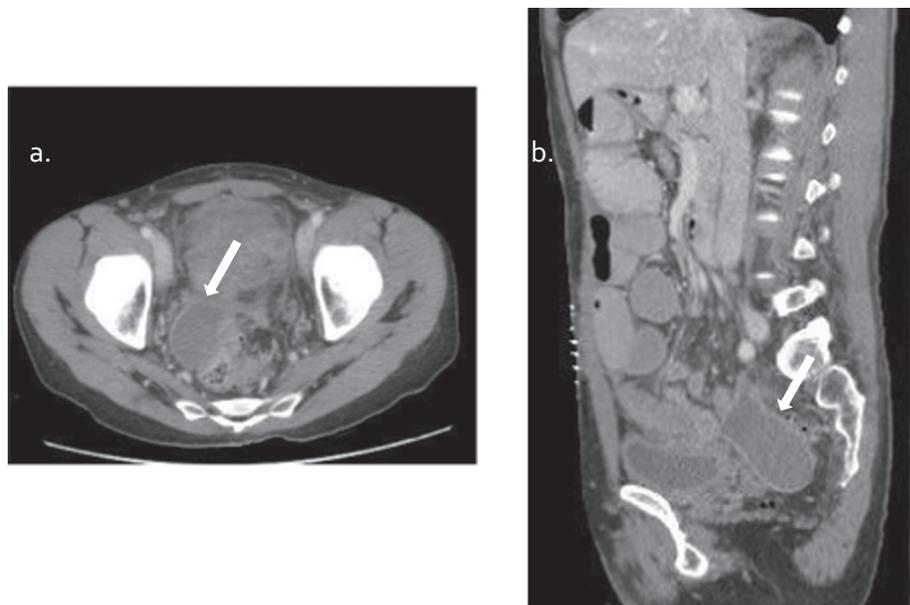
Intrapertoneal abscess: axial (a) and sagittal (b) CT images performed after colostomy demonstrate a well-circumscribed hypodense fluid collection with an enhancing rim consistent with deep pelvic abscess (arrow).
